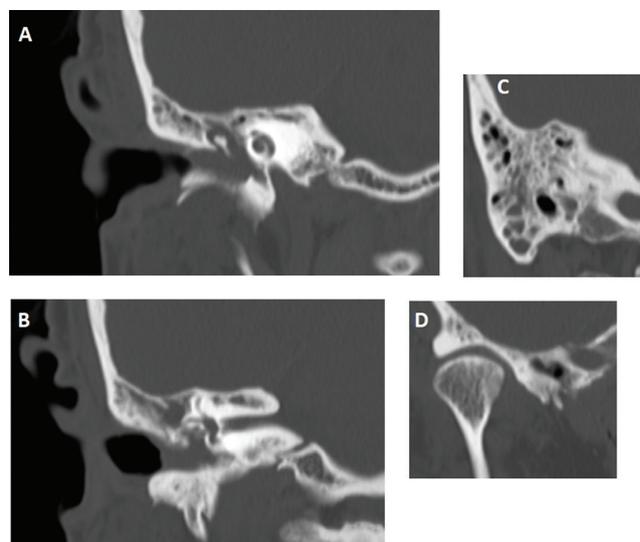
Computed tomography of the right temporal bone. A. and B. Filled tympanic cavity C. Filled mastoid cells. D. Temporomandibular joint.
